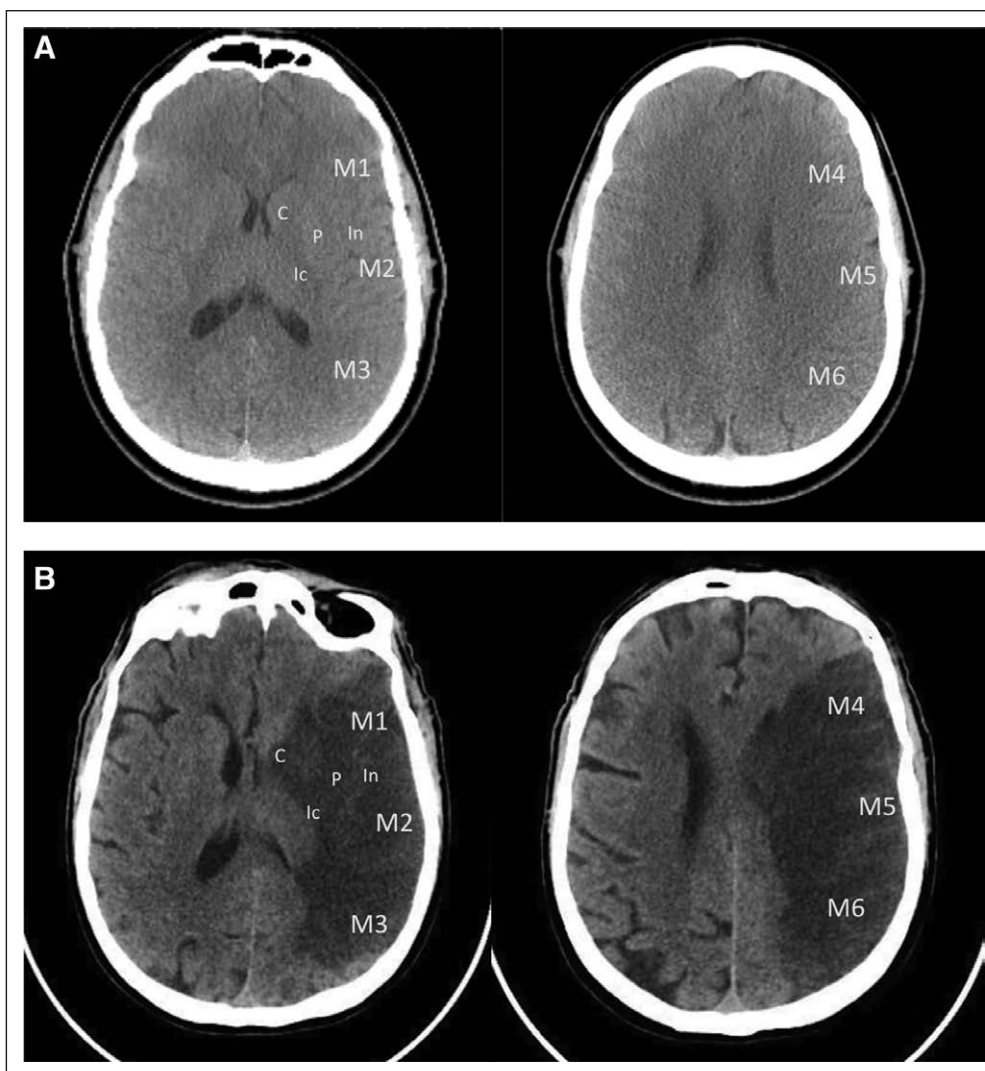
Alberta Stroke Program Early CT Score (ASPECTS). Scoring for each of the 10 zones. Each zone is graded either 1 (normal) or 0 (abnormal). The sum of all zones gives the ASPECTS. A, Normal looking brain with ASPECTS = 10. B, Brain with ischemic changes and ASPECTS less than 6. C = caudate, Ic = internal capsule, In = insular cortex, M = middle cerebral artery, P = putamen.
